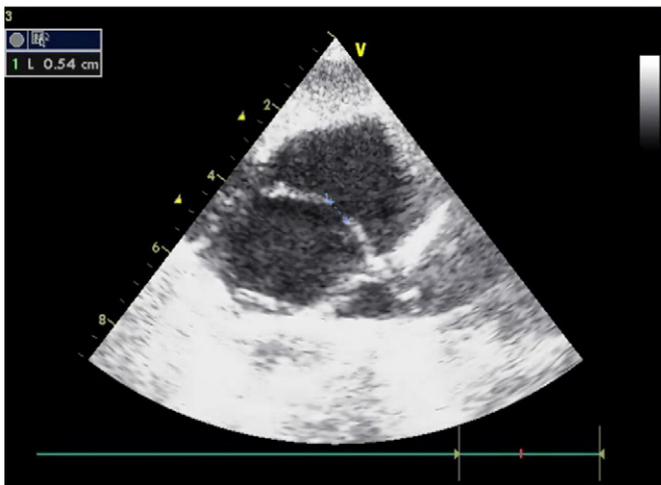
Echocardiographic image of ASD.
